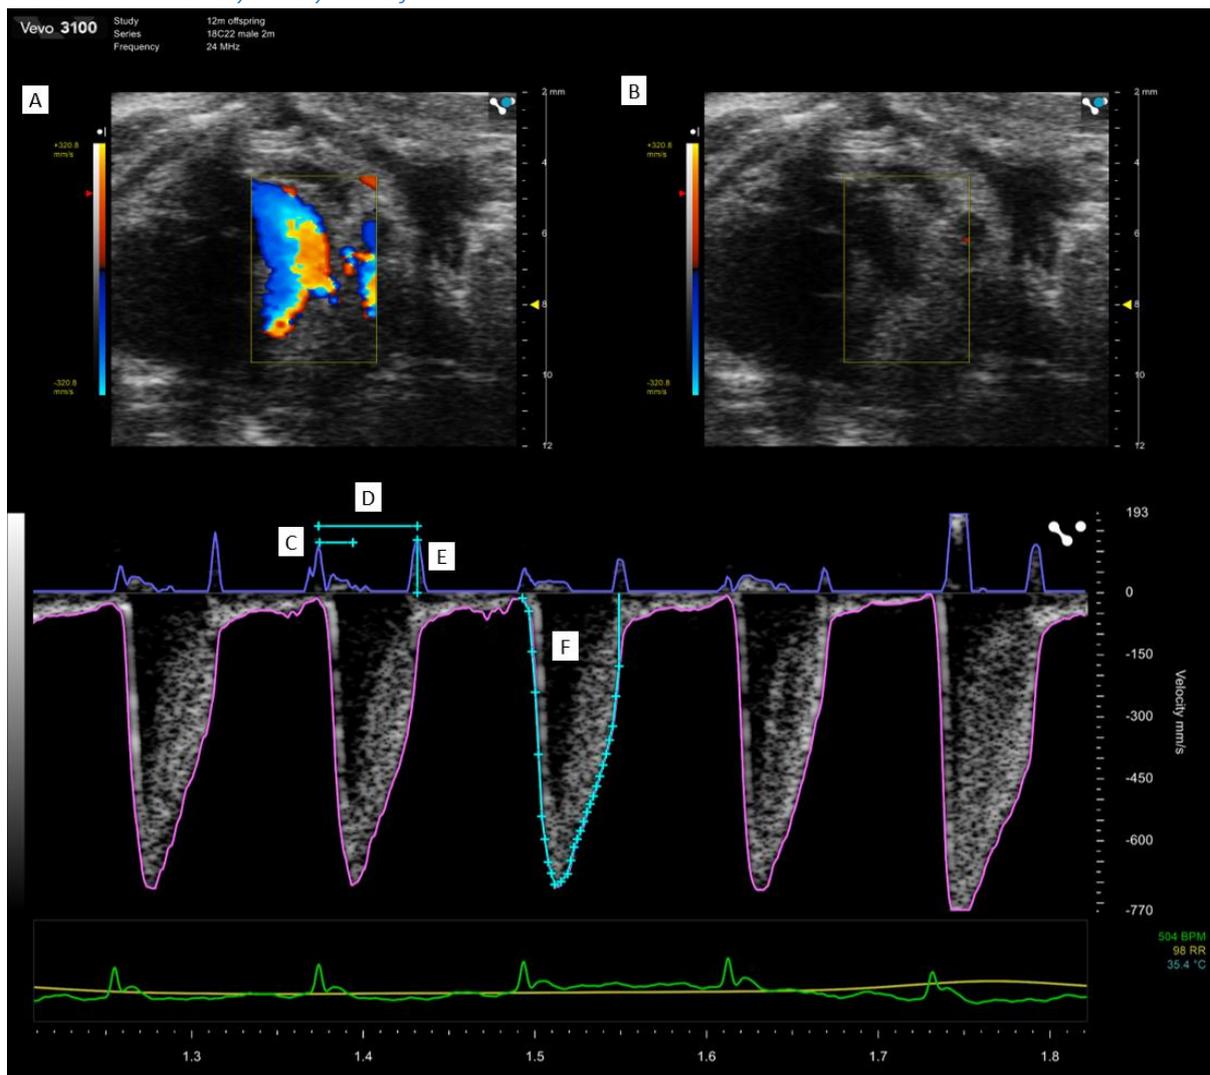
Top: mitral valve pulsed wave Doppler.
